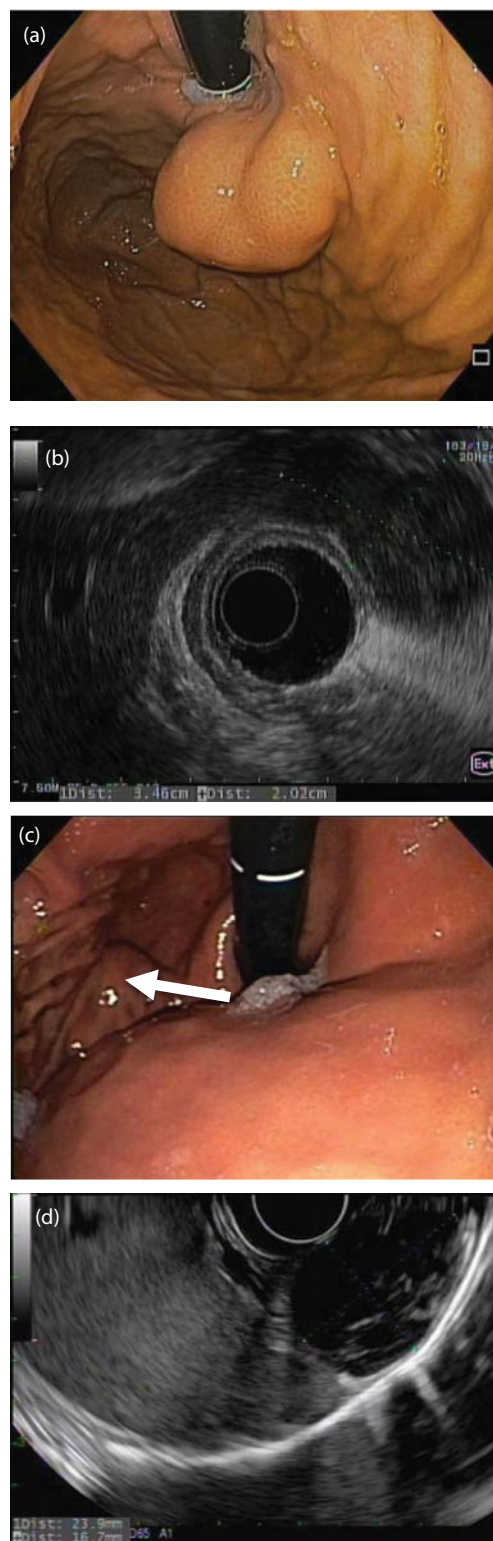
Variable growth patterns of nonadenomatous gastric tumors. Images of a 3.5-cm $\times$ 2.0-cm endophytic leiomyoma adjacent to the gastroesophageal junction on (a) endoscopy and (b) endoscopic ultrasound (EUS). Images of a 2.4-cm $\times$ 1.7-cm exophytic GIST adjacent to the gastroesophageal junction on (c) endoscopy (white arrow) and (d) EUS.
